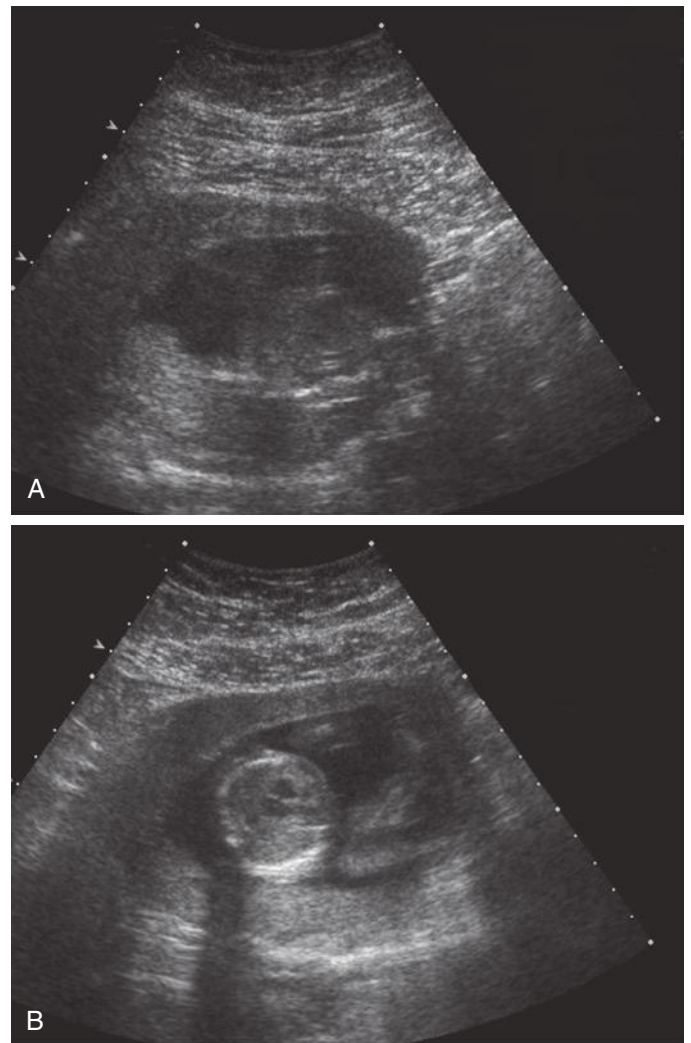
Transabdominal scan of a 16-week fetus in a severely obese patient. A, The fetal chest is seen from the midabdomen through the panniculus. B, The fetal chest of the same fetus is seen through the umbilicus. Note that the ultrasound beam is severely degraded in A. In B, there is less adipose tissue and a clearer image of the fetal heart when imaging through the umbilical area.
